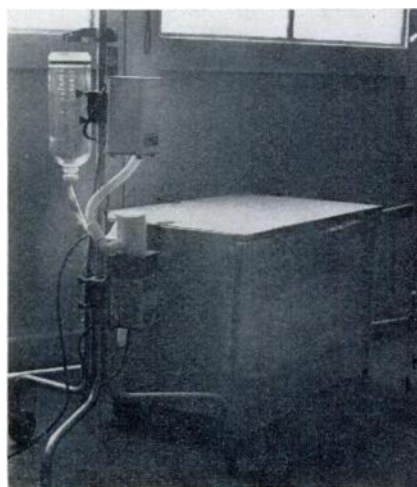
Ultrasonic nebulizer and enclosed cage utilized for vapor therapy.
